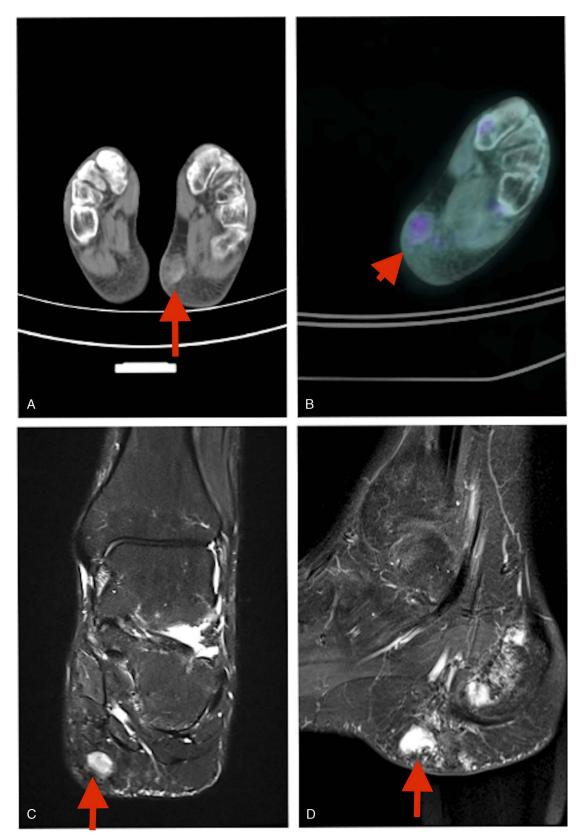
A, Whole-body computed tomography scan showing a heterogeneous, calcified soft tissue mass in the left heel (arrow). B, The lesion was faintly enhanced on the previous positron emission tomography scan but was thought to be trauma related (arrowhead). C and D, The left heel mass shows high intensity on T2-weighted imaging and strong enhancement with contrast medium on the coronal and sagittal views of the left ankle magnetic resonance imaging (arrows).
